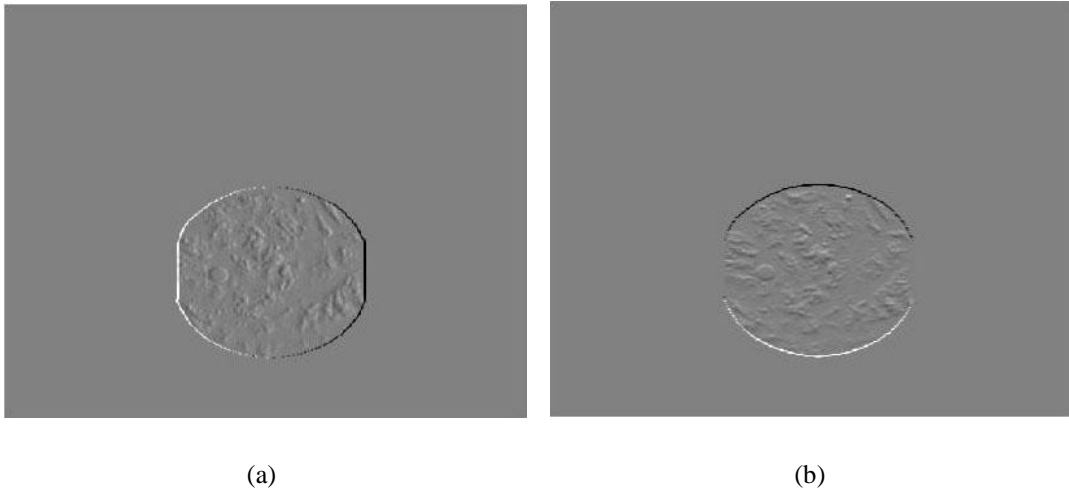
Gradients of CT image set (a) Gradient image $\frac{\partial I}{\partial x}$ (b) Gradient image $\frac{\partial I}{\partial y}$
